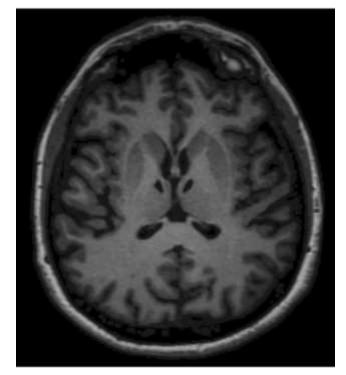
Reduced Self-awareness Case Report: Magnetic resonance imaging (MRI). G.A.'s MRI shows lacunar thalamic infarcts symmetrically located within the polar and paramedian vascular territories of both thalami. Lesions are well-demarcated and isointense to cerebrospinal fluid as observed in chronic settings. The anatomical symmetry was the distinctive feature in this patient.
